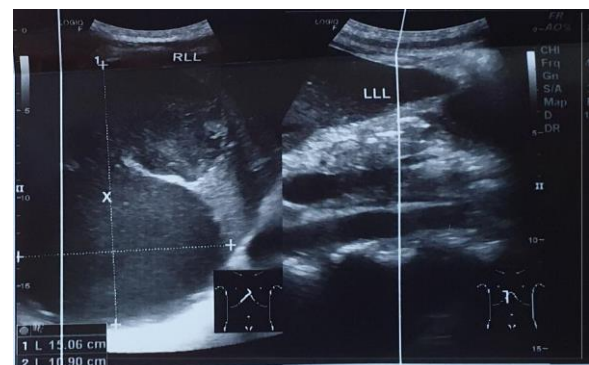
Abdominal ultrasound found cystic lesion in right lobe of liver suspected as liver abscess.
